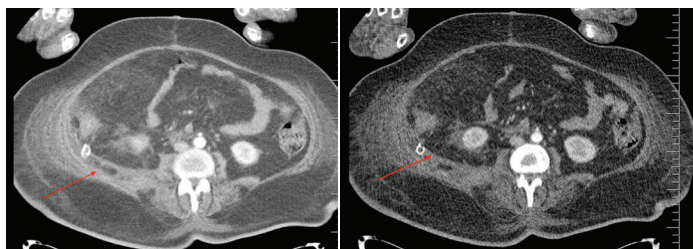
Retroperitoneal abscess completely disappeared on abdominal CT at postoperative days 7 and 14.
